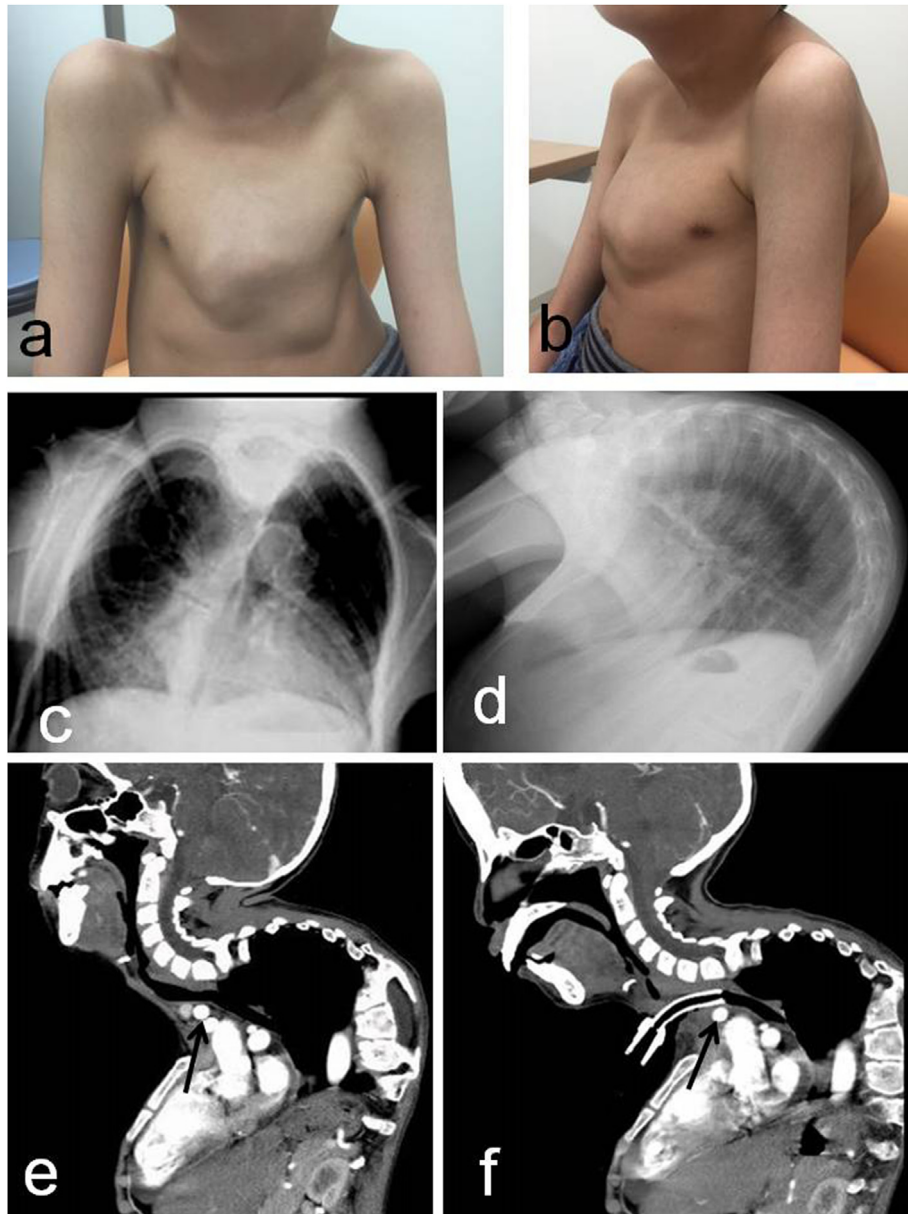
Physical findings and radiological examinations. a, b: The patient's thorax is armor-like. c, d: An X-ray film shows that the cervical spine is strongly curved anteriorly and the thoracic spine is strongly curved posteriorly. e: Contrast computed tomography (CT) shows compression of the trachea from the back and cephalad displacement of the brachiocephalic artery (black arrow: brachiocephalic artery). f: After tracheostomoplasty, CT shows the tracheal tube runs vertically backward at the skin level (black arrow: brachiocephalic artery).
